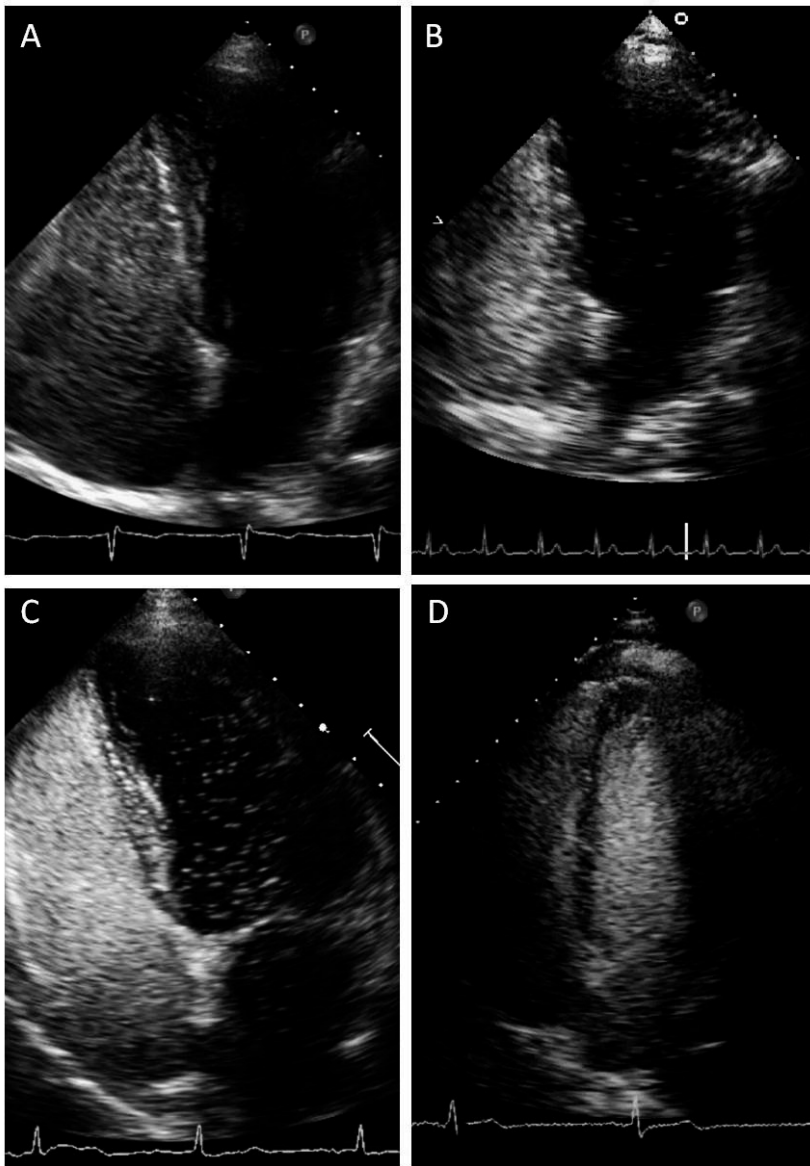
Different degrees of left ventricular opacification on contrast echocardiography following injection of agitated saline in patients with intrapulmonary shunts; A: Normal, no appearance of 'microbubbles' in the left ventricle; B: Small shunt (grade 1; < 30 microbubbles); C: Moderate shunt (grade 2; 30-100 microbubbles); D: Large shunt (grade 3; >100 microbubbles).
